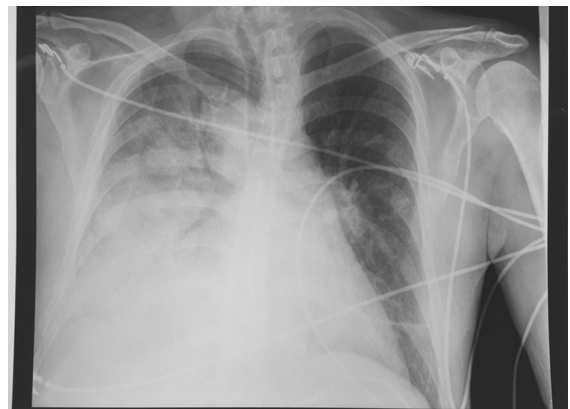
Chest radiograph: consolidative lesions with central lucency involving basal and medial lobes of the right lung
